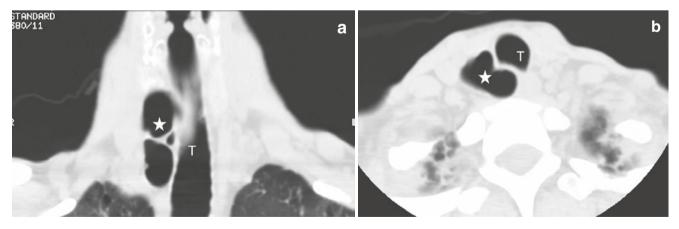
(a, b) Coronal and axial CT images showing a large rare but asymptomatic right tracheal diverticulum (asterisk) with mass effect. T: trachea. (c) Small tracheal diverticulum (arrow) in another patient
